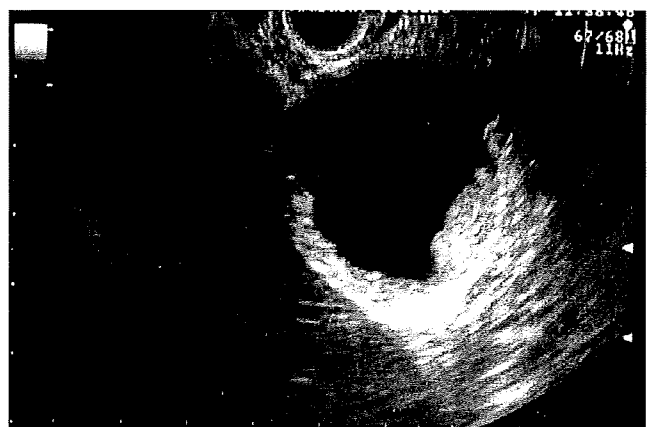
Ultrasound image of gallbladder carcinoma: sessile protruding lesion. Depth of tumor invasion is to the subserosa
